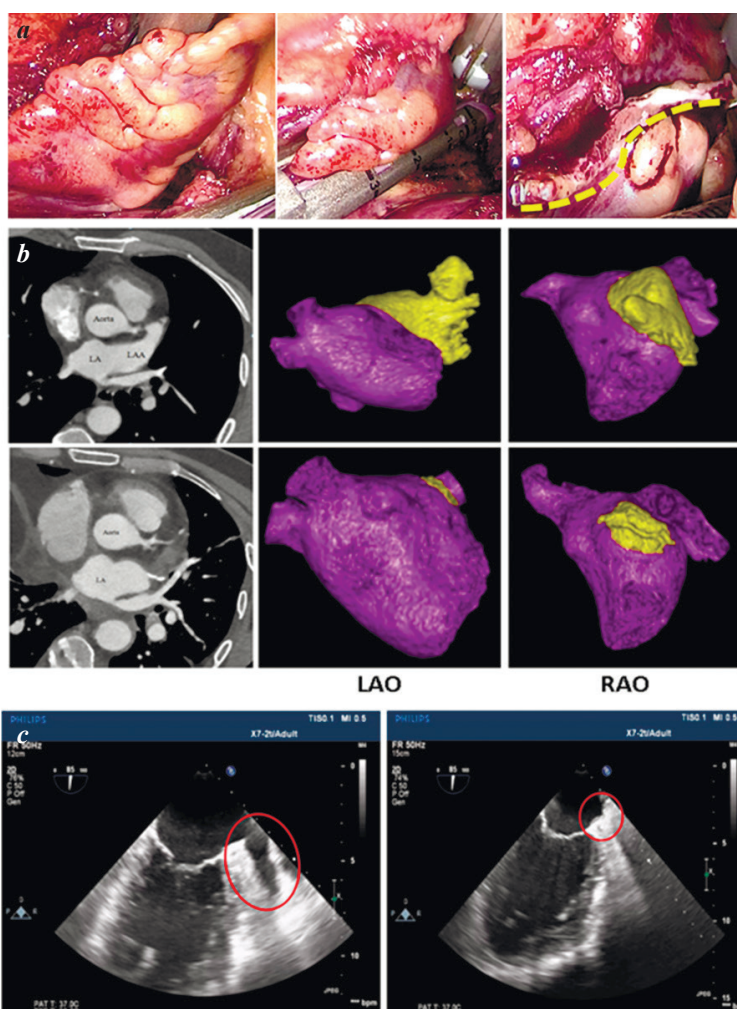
Left atrial appendage amputation (a), the yellow dotted line marks the resection line of the LA appendage (intraoperative photos). MSCT (b) with contrast of the left atrium and left atrial appendage with 3D reconstruction before (top) and after (bottom) surgery in right and left oblique projections (RAO and LAO). The residual part after amputation of the left atrial appendage is marked in yellow. Intraoperative transesophageal echocardiography (c) before and after LA appendage amputation.
